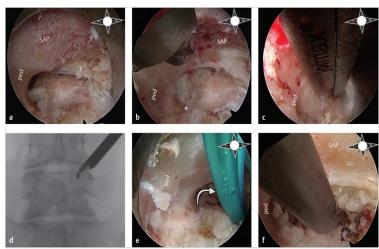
The transforaminal technique is shown in Figure 7. (a) The ped and the lateral aspect of the SAP are seen in the first endoscopic image of the caudal pedicle (ped). (b) The ventral SAP is further resected with a cutting burr. The major anatomical landmark at the caudal index level may be identified without a doubt with the use of (c) a Kerrison rongeur placed over the pedicle and (d) confirmation of its correct position by AP X-ray. (f) Using a rotating maneuver (asterisk), bluntly dissect the lateral recess immediately rostral to the pedicle
